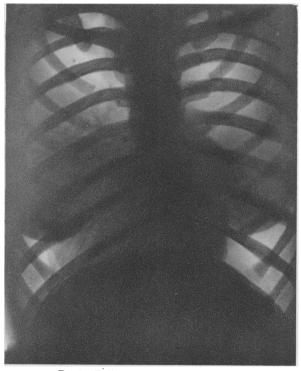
Radiograph taken April 22nd, 1932.
